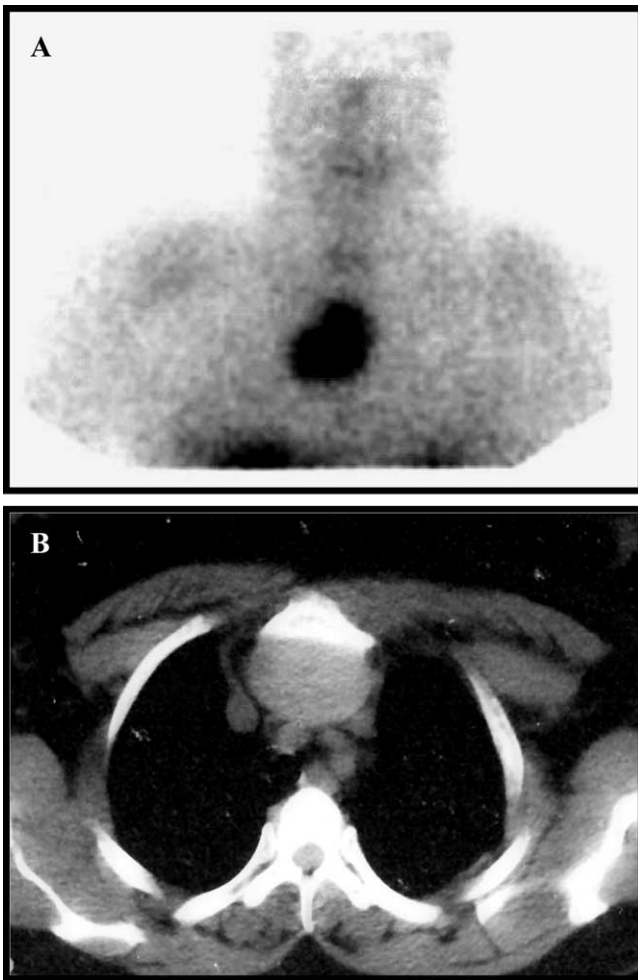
Somatostatin receptor scintigraphy in thymoma. (A) Large thymic mass showing intense and homogeneous [^{111}In -DTPA 0] octreotide uptake, which positively correlated with somatostatin receptor expression within malignant epithelial cells of this thymic mass. (B) CT slice of the same lesion allowing definition of the borders of the mass, which is not dissociable from the sternum anteriorly.
